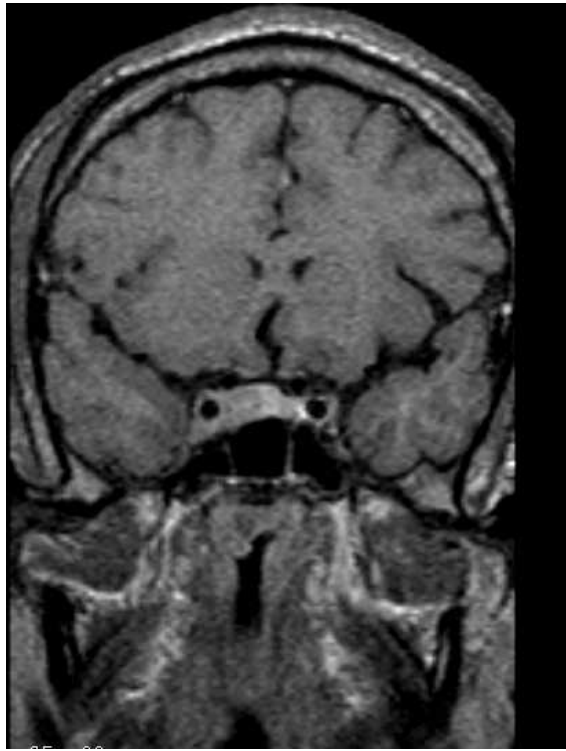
(Case 3): MRI (T1 coronal with gadolinium) showing a pituitary microadenoma with invasion of the right cavernous sinus.
